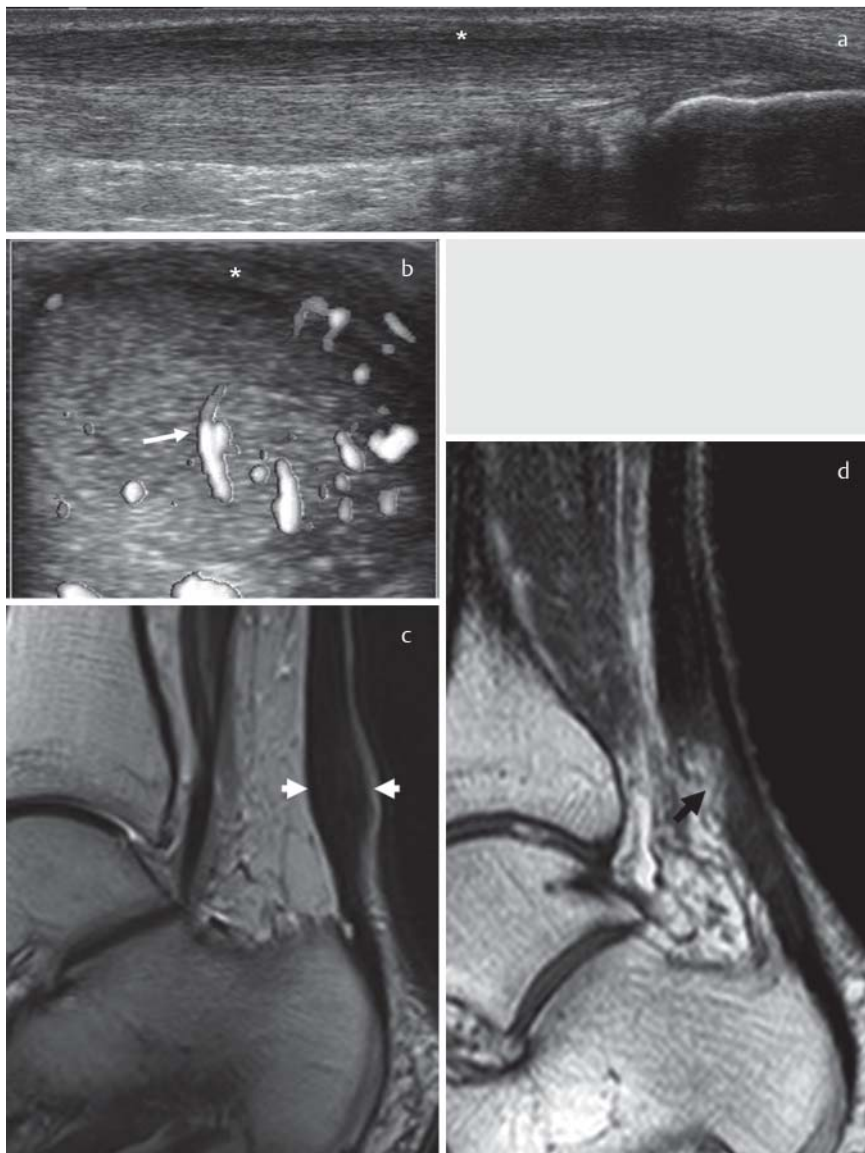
a shows the typical spindle-shaped thickening of the Achilles tendon associated with degeneration, as well as focal hypoechoic areas in a 44-year-old patient. b shows intratendinous neovascularization (white arrow) associated with tendinopathy. An associated paratenonitis is present in terms of thickened tendinous boundary (marked by the white asterisk). c In comparison to ultrasound, a sagittal T2-weighted MR image also shows a spindle-shaped thickening and areas of signal alterations within the tendon (white arrows, c) in a 46-year-old patient with midportion tendinosis. d In contrast, a partial rupture of the Achilles tendon in a 77-year-old patient is shown in a sagittal T1-weighted MR image d. The fibrillar pattern of the Achilles tendon is interrupted as shown by the black arrow.
